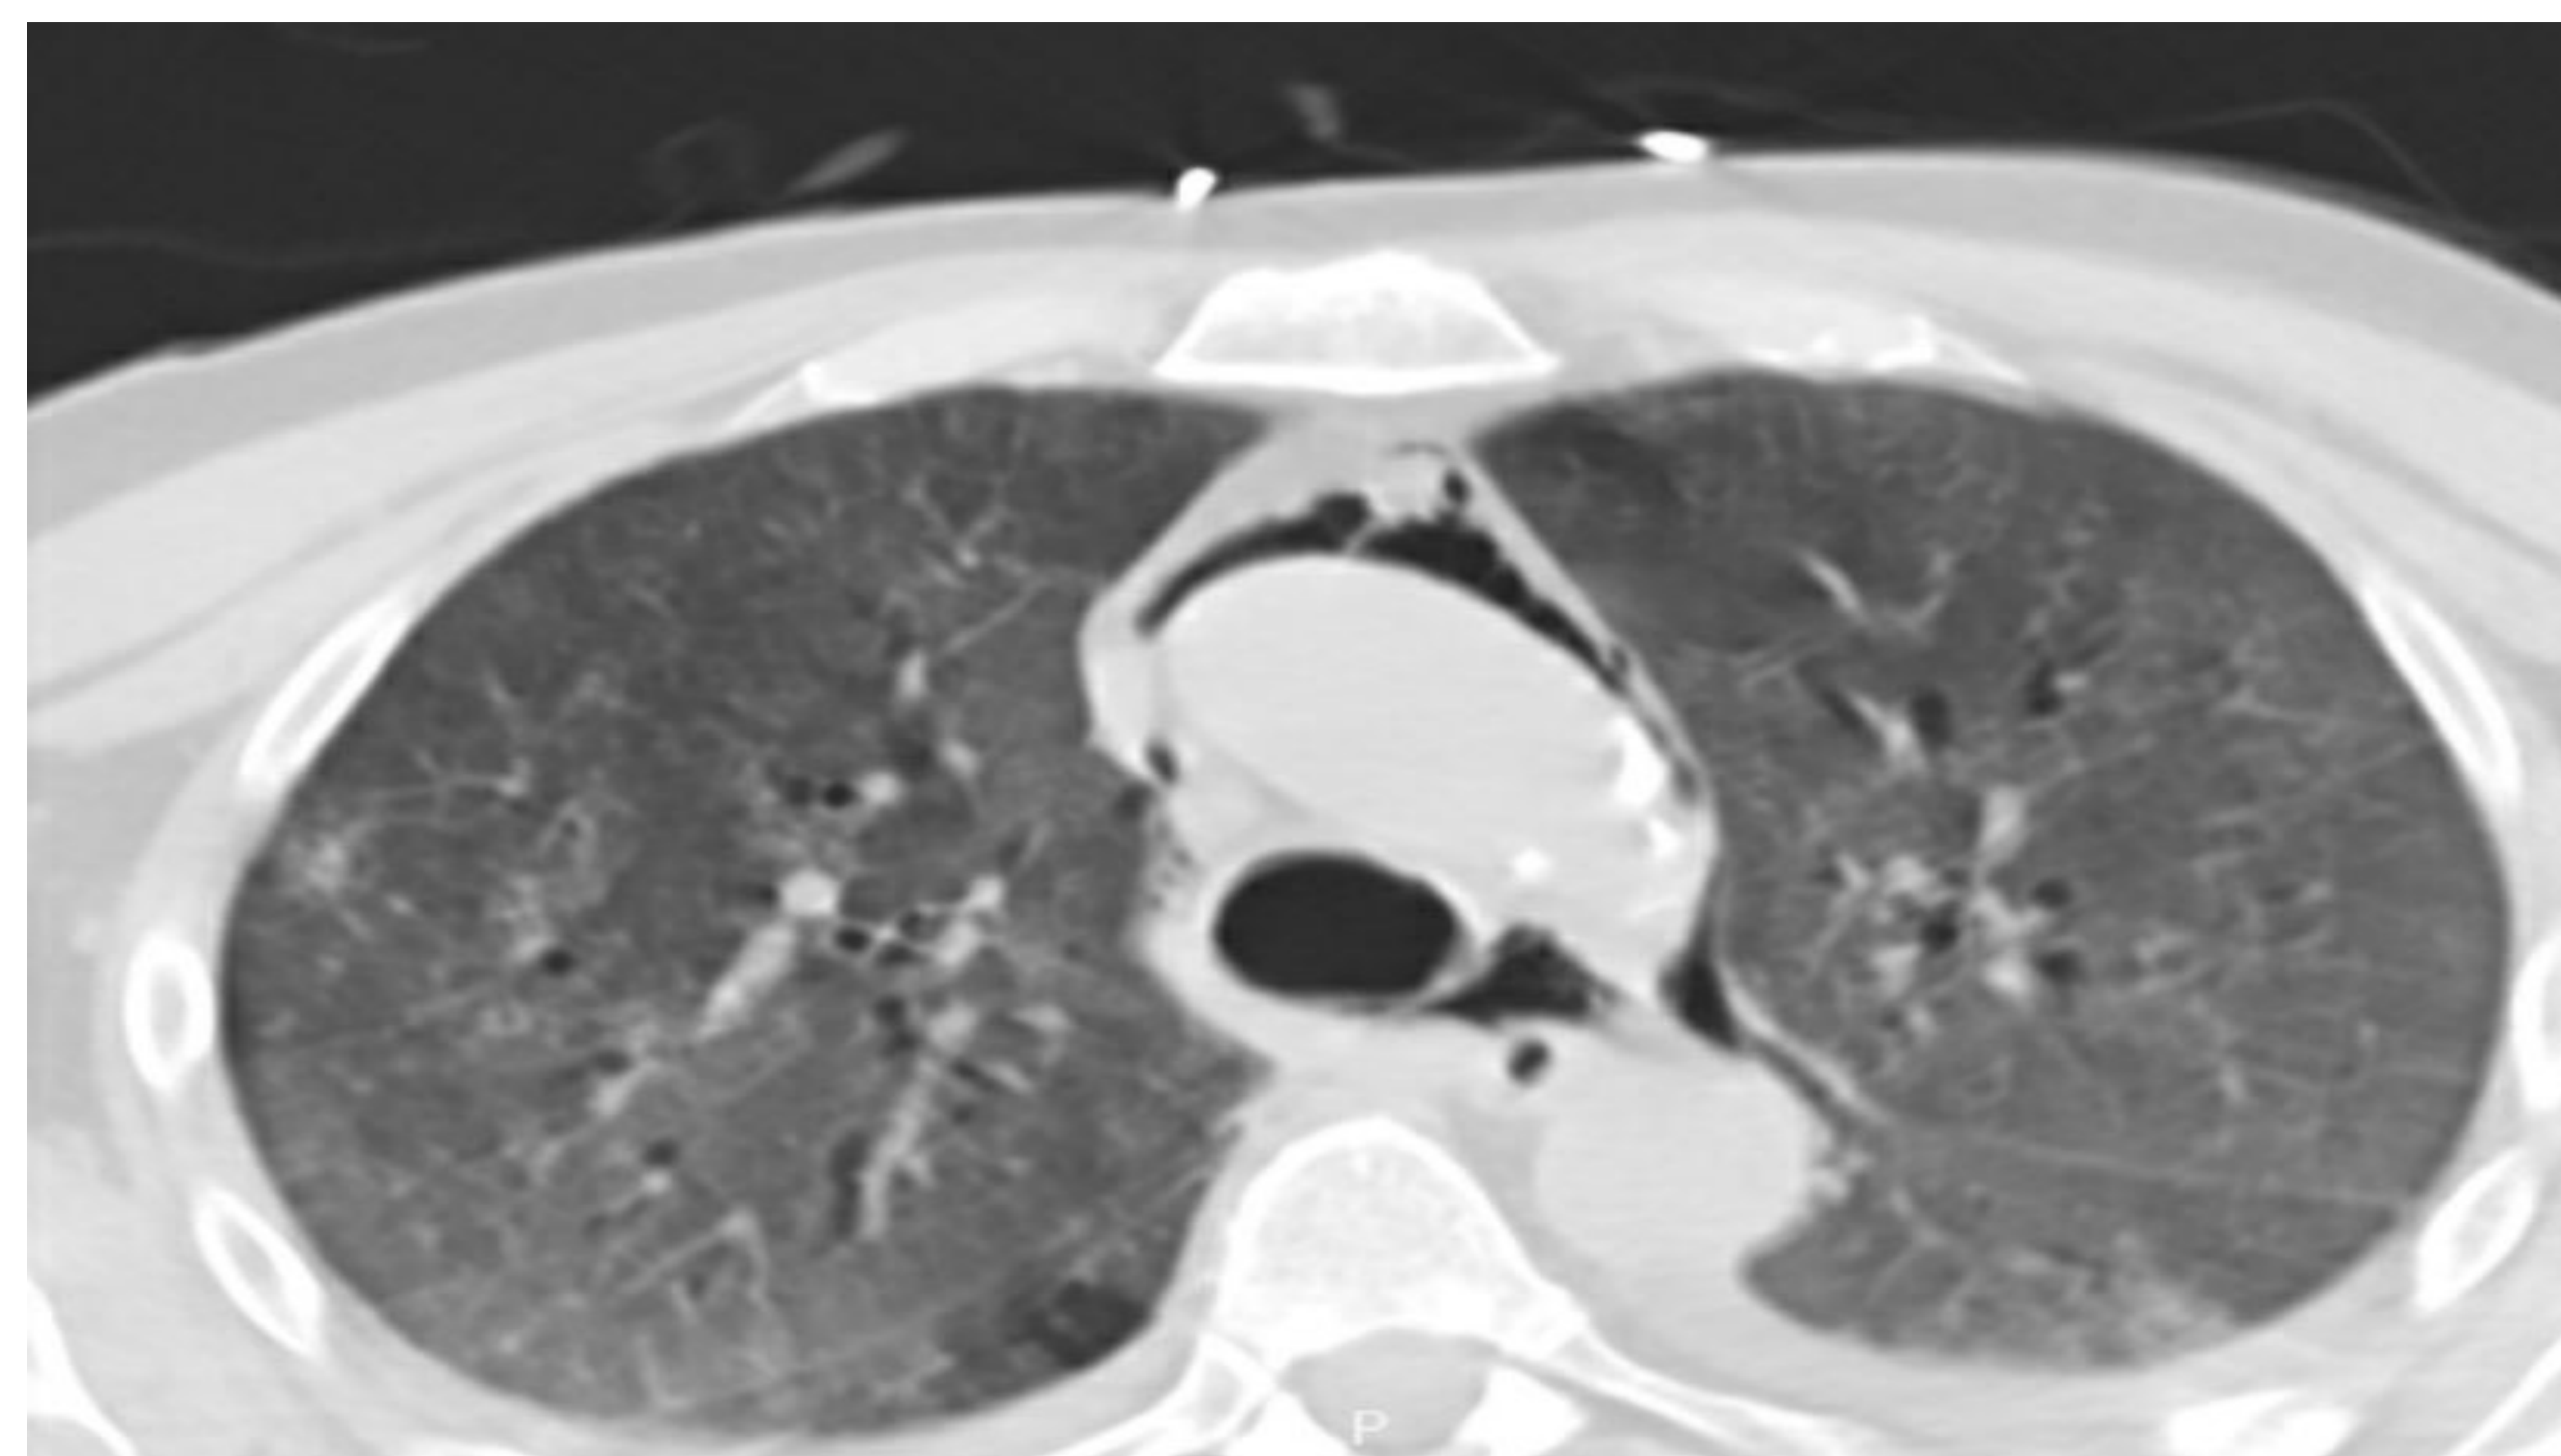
CT Chest axial view showing pneumomediastinum.
